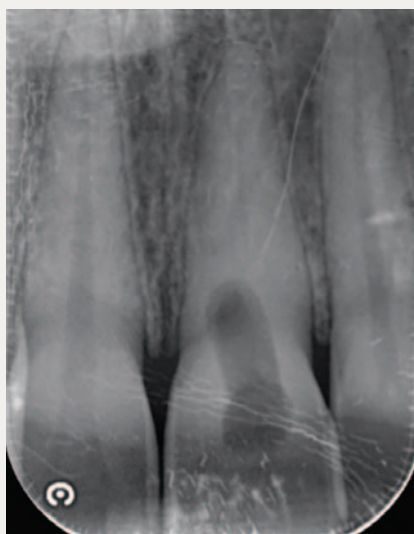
Periapical radiograph 2.
